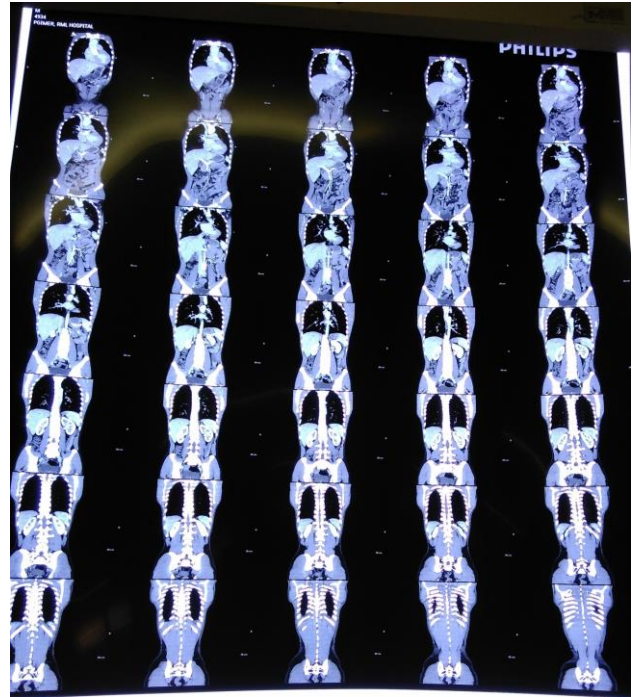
CT chest and aortography showing coarctation of aorta (in coronal plane).
